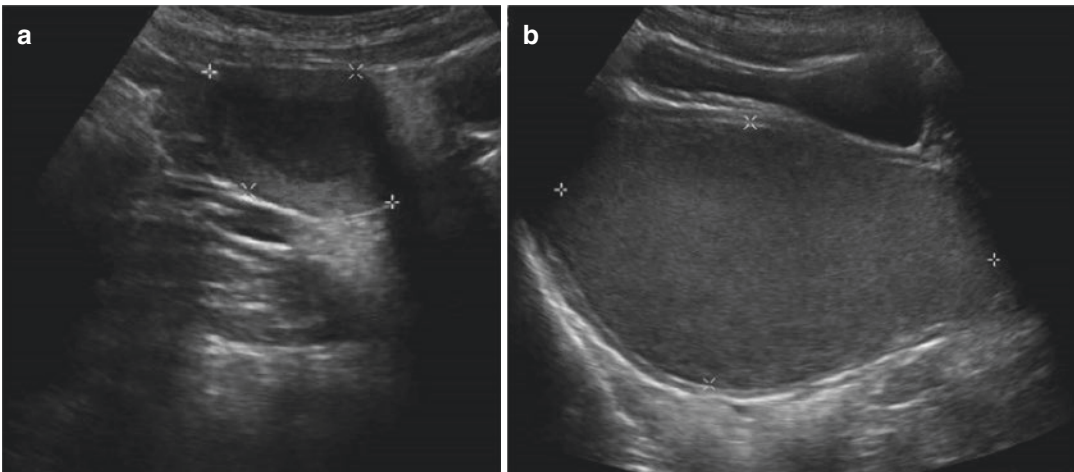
(a, b) Pelvic ultrasound of an obstructive Müllerian anomaly. Diagnostic ultrasound in a patient with primary amenorrhea and cyclic pelvic pain showing hematometra (a) and large distended hematocolpos (b).
